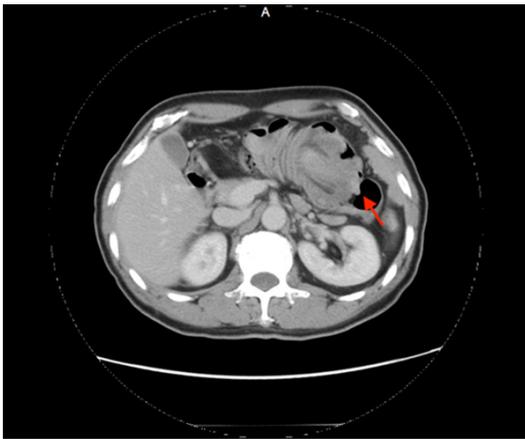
Computed tomography findings. Focal irregular wall thickening at transverse colon with lymphadenopathy, suggesting adenocarcinoma.
